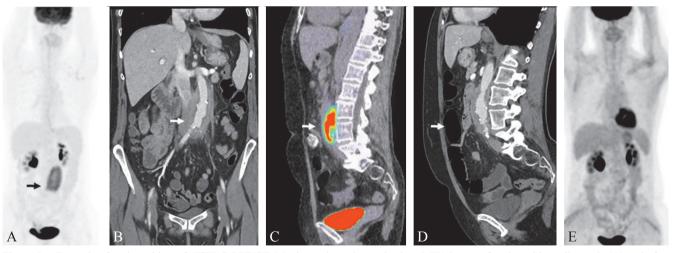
Example of peri-aortitis on [¹⁸F]FDG-PET/CT. Maximum intensity projection (MIP) image of peri-aortitis at diagnosis (A) and after 6-months of low-dose steroid therapy (E), showing complete remission. Coronal and sagittal contrast-enhanced CT images at the time of diagnosis (B, D), showing a tissular infiltration surrounding the infrarenal aorta with both shrinking and moderate dilation of its lumen. These CT findings correlated with the hypermetabolic activity observed on [¹⁸F]FDG-PET/CT (C).
